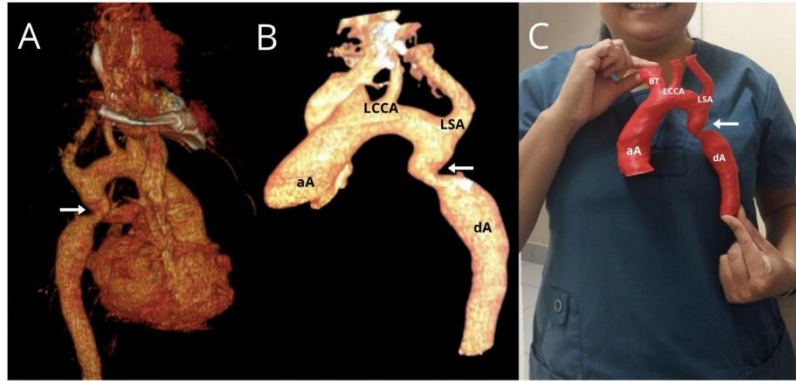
3D reconstructed CT angiography of the aortic arch showing focal narrowing (arrow) of the descending thoracic aorta, located approximately 15 mm distal to the origin of the left subclavian artery in a posterior view (A) and anterior view (B) (C). (C) 3D-printed aortic arch reconstruction model. Ascending Aorta (aA), Left Common Carotid Artery (LCCA) Brachiocephalic Trunk (BT), Left Subclavian Artery (LSA), Descending Aorta (dA).
